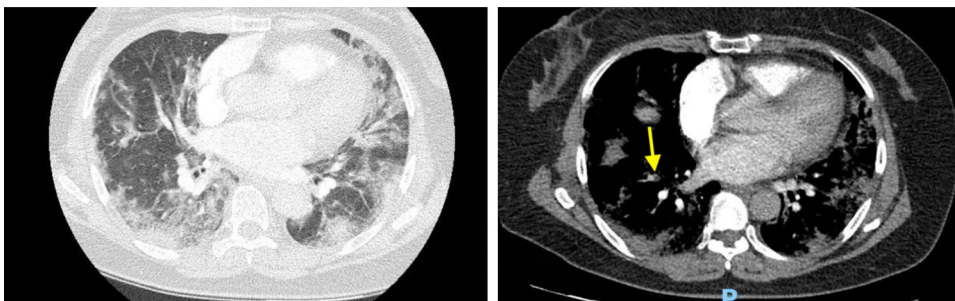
CT angiogram performed in a 57-year-old patient who tested positive for SARS-CoV-2 in April 2020 and was hospitalized in the infectious disease unit for acute respiratory failure. Left panel: typical of COVID-19 images of the parenchymal window showing ground glass opacities in the lung bases. Right panel: mediastinal window showing the presence of a small endoluminal defect in the right lower lobe sub-segment indicative of a pulmonary embolism. Dr Sebuhyan Maxime, UF04 Saint-Louis hospital.
